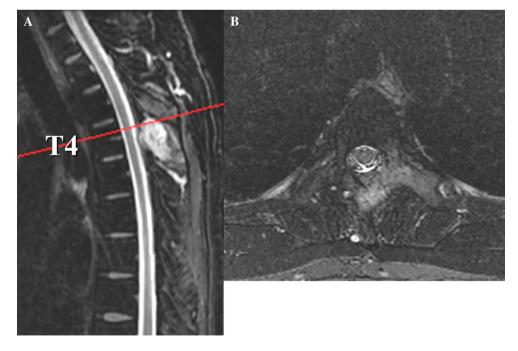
Preoperative T2-weighed MRI showing T4 metastasis. a Sagittal view, b axial view. The tumor invaded into the vertebral body through left pedicle
